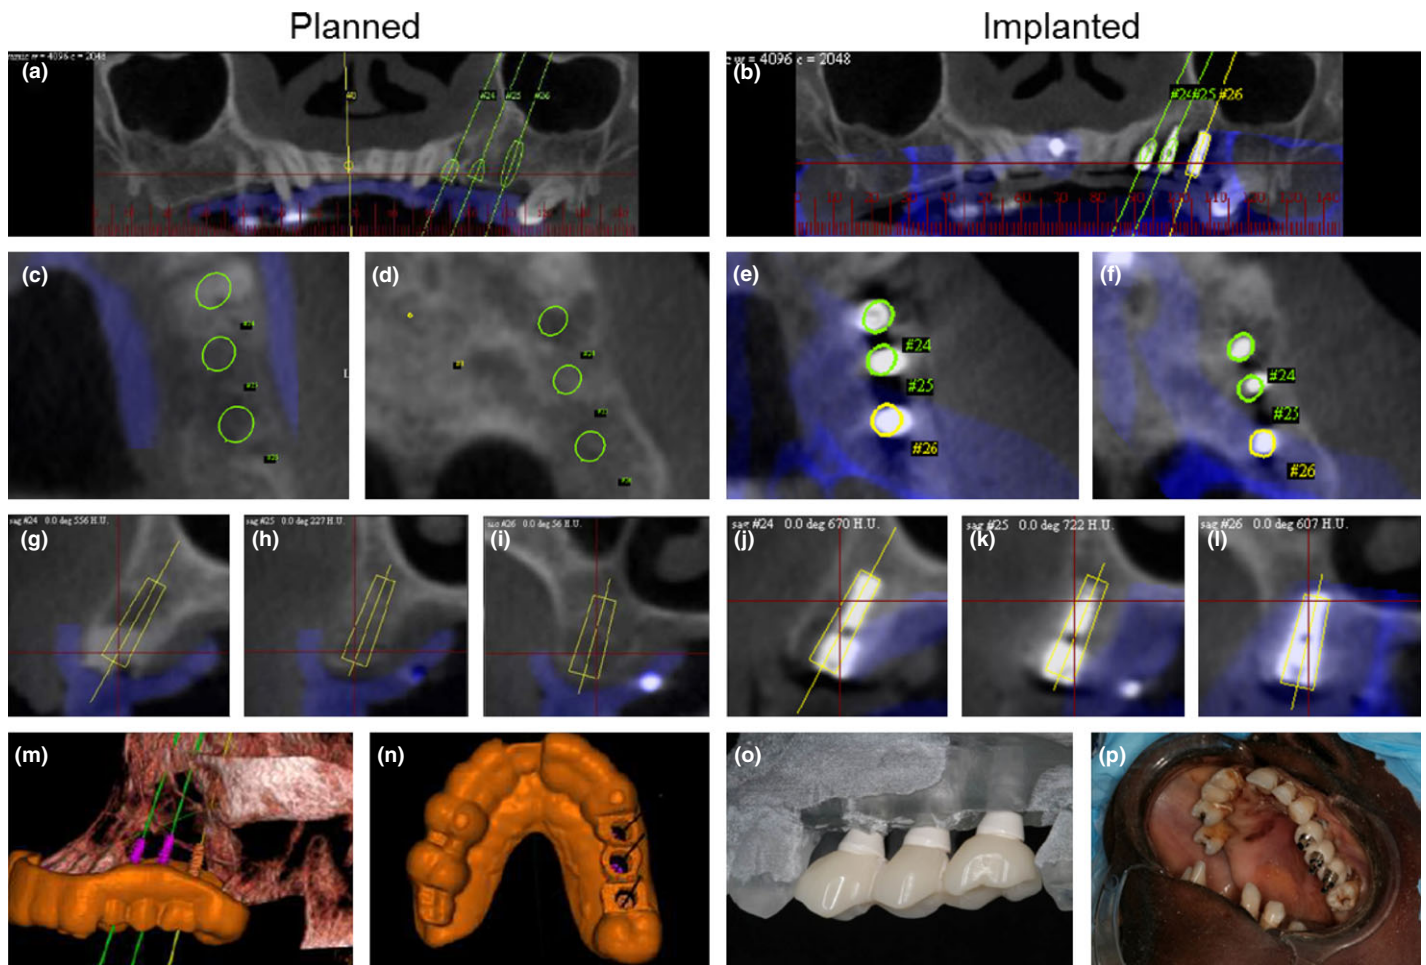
Case showing planned (a, c, d, g, h, i, m, n) and implanted (b, e, f, j, k, l, o, p) images of guided implant placement in the maxilla. CBCT scans were taken of patients before (a) and after (b) implant placement, showing outline of planned implant (a, b) and location of the actual implant (b). Cross-sectional slices for location analysis were performed for planned (c, d) and implanted (e, f) implants at the coronal (c, e) and apical (d, f) levels. Close-up images of each implant placed from original CBCT scans (a, b) are shown before (g–i) and after implantation (j–l). A 3D reconstructed view of the maxilla with surgical guide (m, n) was used for implant placement. A model of the maxilla with planned implants (o) was used in selection of appropriate crown size that transferred to each finished case (p).
